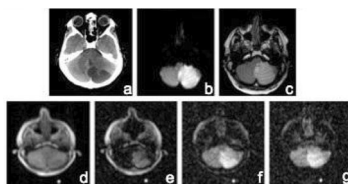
CT, 3T DWI MRI and FFC-MRI images from a patient admitted with a posterior inferior cerebral artery territory infarct. a) CT, b) 3T DWI, c) 3T T2 weighted image at 96 hours after onset. d-g) FFC-MRI images at 200 mT, 20 mT, 2 mT and 0.2 mT
